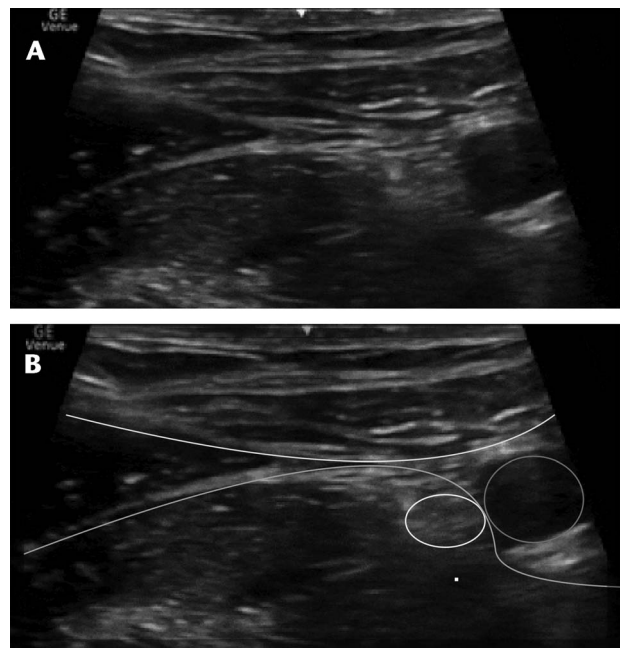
A, Ultrasound image showing anatomy of the FICNB. B, Colorized image showing the femoral nerve (yellow) adjacent to the femoral artery (red). Fascia lata (blue) is superficial to the sartorius muscle, and fascia iliaca is between sartorius and iliacus, separating the nerve from the artery.
